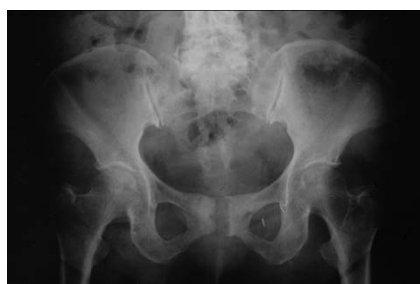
Anteroposterior plain radiograph of the pelvis at the 5-years follow-up observation showed no further erosion of bone.
